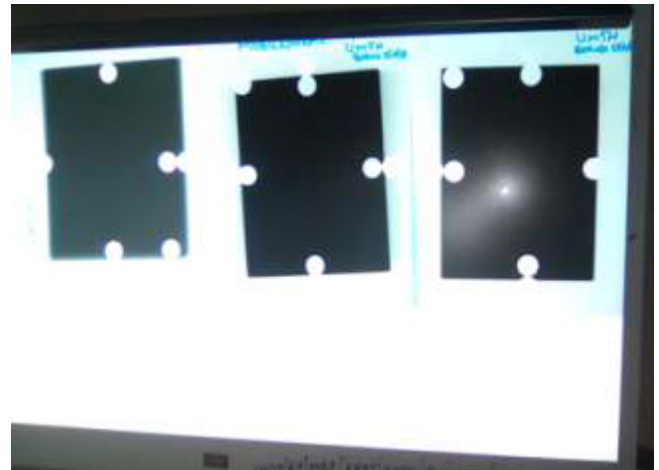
Radiograph for light beam collimation test
